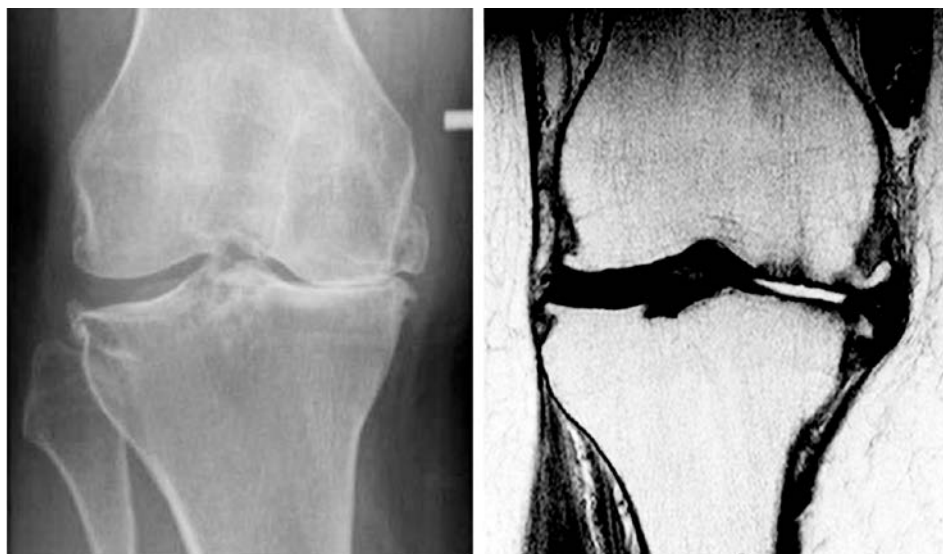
Radiographic examination of the knee by X-ray (left) and T1-weighted magnetic resonance image (right).
